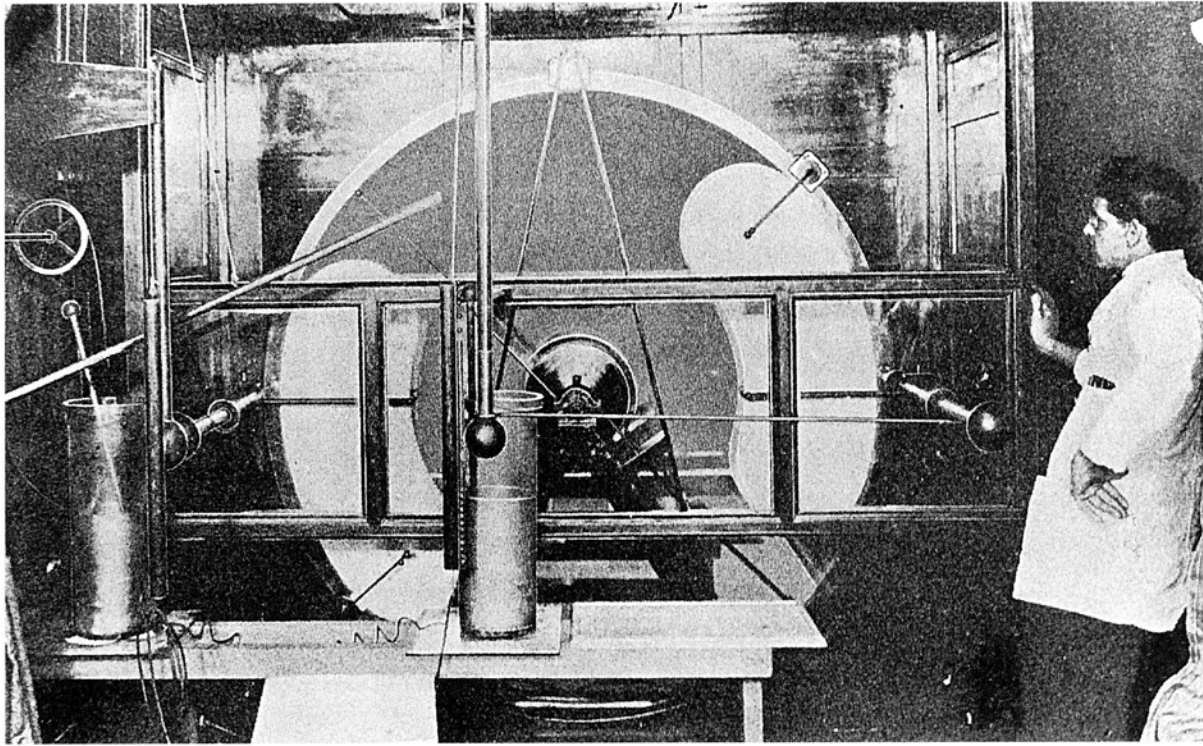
Large static machine of the Holtz type with front panel removed. (From Williams, F.H., *The Roentgen Rays in Medicine and Surgery*, New York, McMillan and Co., 1901.)
